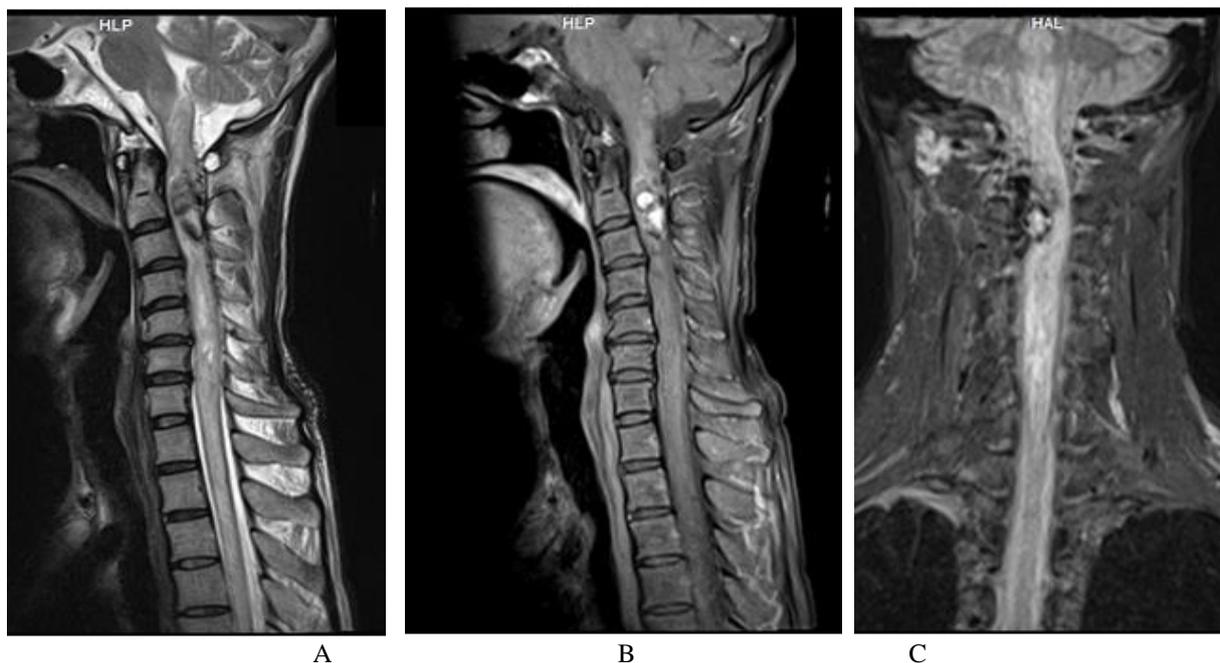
MRI of cervical spine of a 42 years old male
